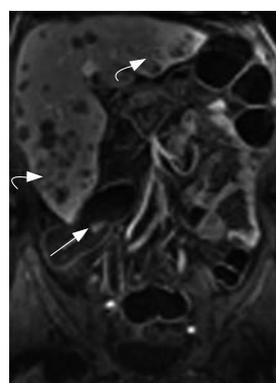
66-year-old man with history of right lower quadrant pain. Coronal gadolinium enhanced T1-weighted image shows a 1.1 cm polyp (white arrow) covered by residual water in the ascending colon and multiple hepatic metastases (white curved arrows).
